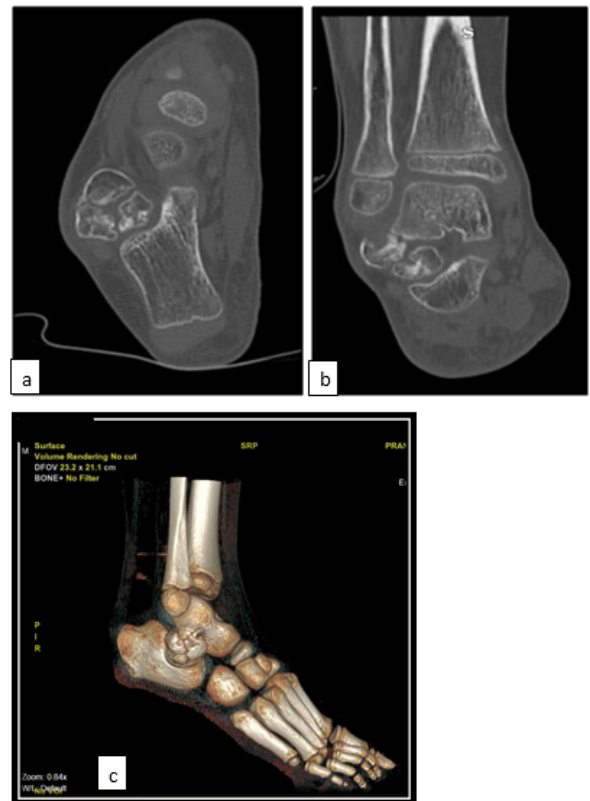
CT Scan showing a): Axial view and b): Coronal view; c): 3D reconstruction showing the extent and bony nature of the swelling
